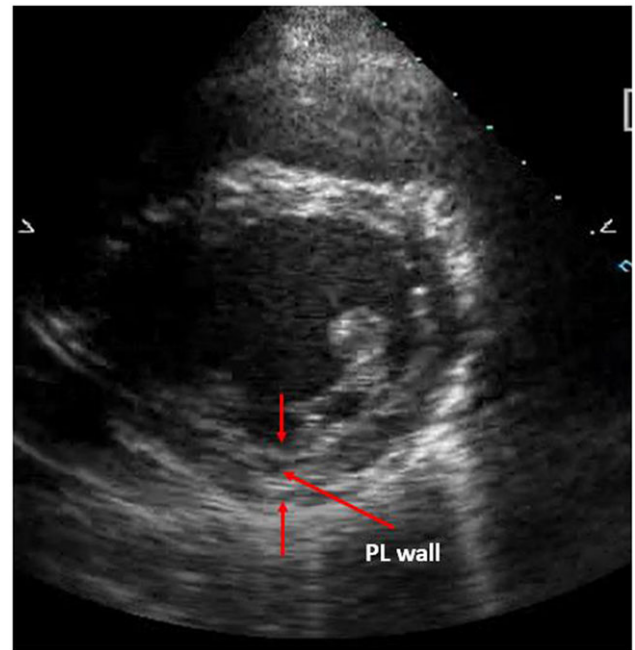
Echocardiographic image after 2 months of treatment showing resolution of the myocardial oedema with a normal thickness of the posterolateral (PL) wall (red arrows).
